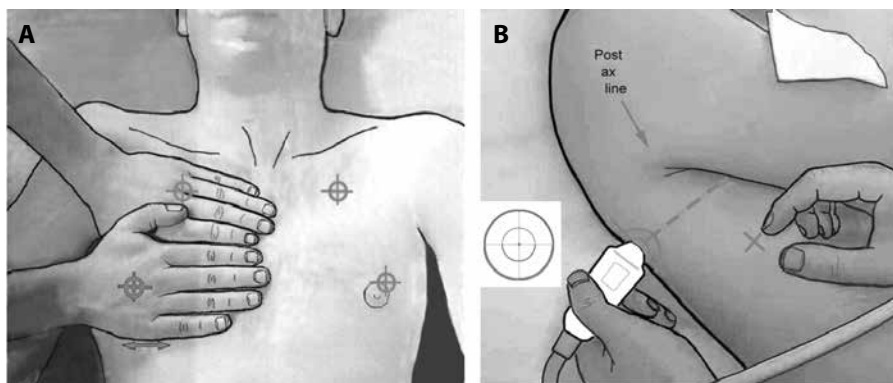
Areas of investigation showing the standardised examination BLUE points; A — two hands placed this way (size equivalent to the patient's hands, upper hand touching the clavicle, thumbs excluded) correspond to the location of the lung, and allow three standardised points to be defined. The upper-BLUE point is at the middle of the upper hand. The lower-BLUE point is at the middle of the lower palm; B — the PLAPS point is defined by the intersection of a horizontal line at the level of the lower BLUE point and a vertical line at the posterior axillary line. Small probes allow positioning posterior to this line as far as possible in supine patients, providing more sensitive detection of posterolateral alveolar or pleural syndromes (PLAPS). The diaphragm is usually at the lower end of the lower hand. Adapted from 'Lung ultrasound in the critically ill' [11]
